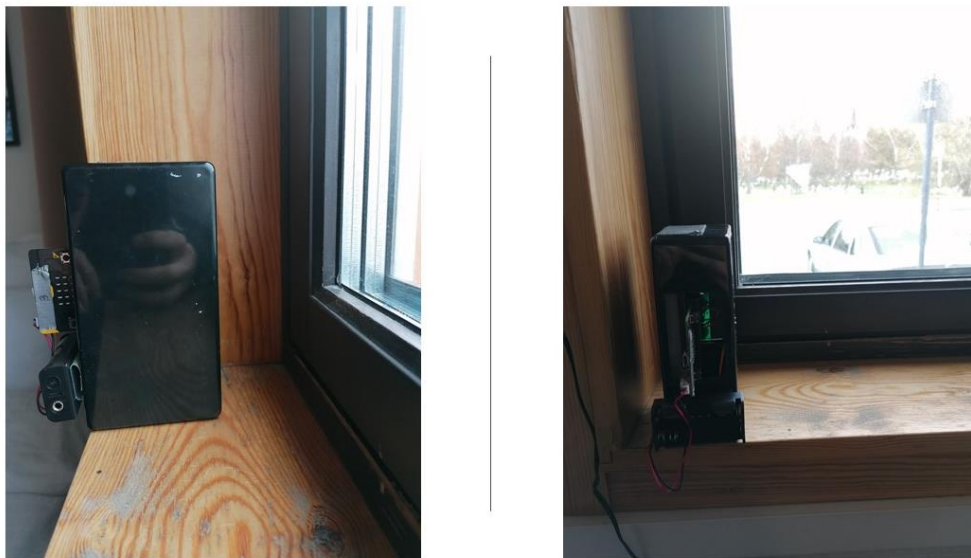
Mounting of ultrasonic sound sensor.
